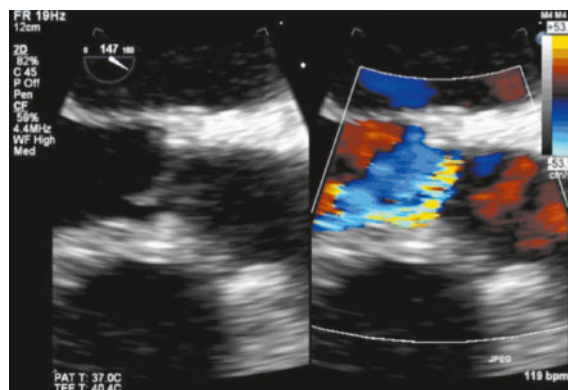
Transoesophageal echocardiography in the long axis view with zoom on an aortic bioprosthesis. Acute transvalvular regurgitation due to flail leaflet (right coronary position) after an endocarditis. There is severe eccentric regurgitation due to the flail.
